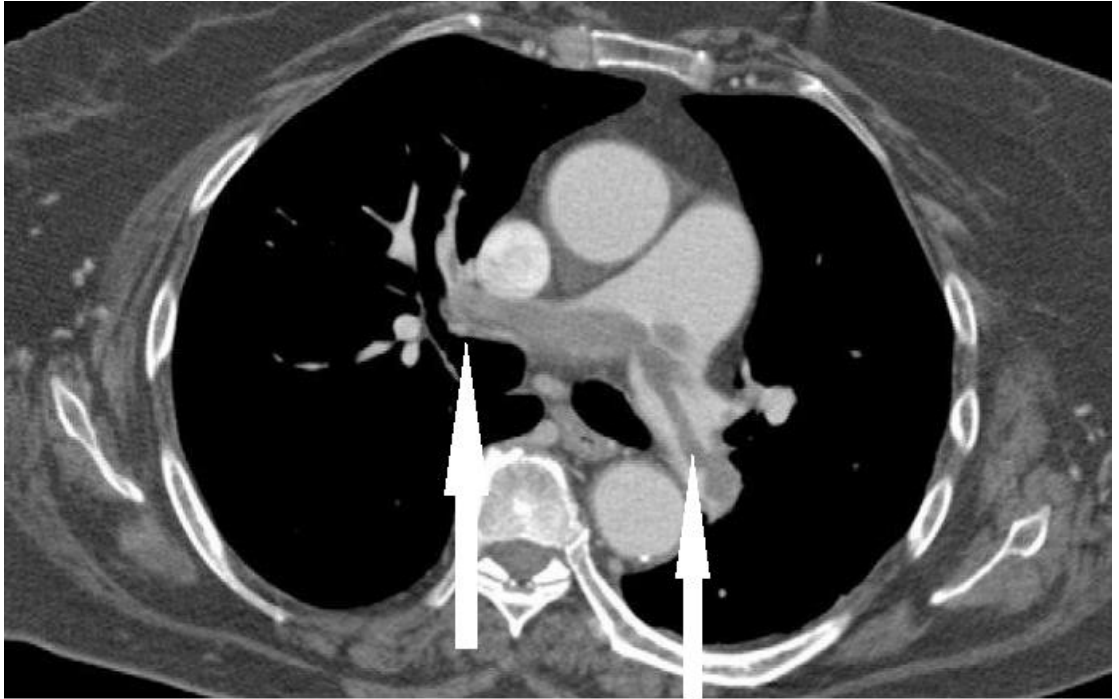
A 63 year's female axial CT image of the chest demonstrating acute minor pulmonary embolism in the both side of main pulmonary artery.
